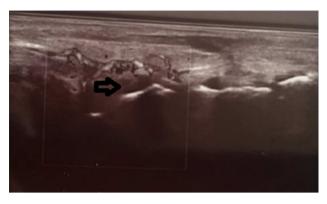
USG of knee joint of case 1 showing marked synovial hypertrophy (arrow) with positive Doppler activity and effusion.
